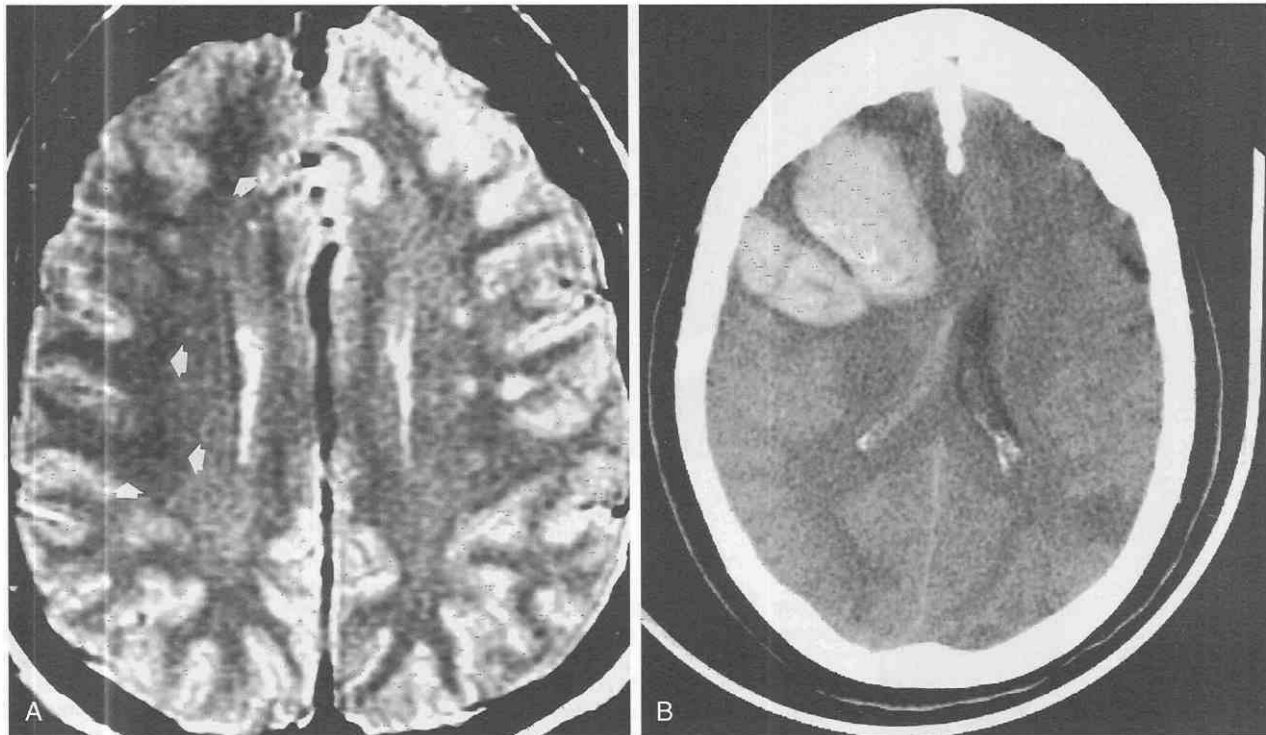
Acute left-sided weakness. A, T2-weighted axial image shows extensive subcortical low signal in the right frontal lobe (arrows). B, Unenhanced CT 36 hours later shows development of right frontal hematoma. Hypointense changes on T2-weighted images appear to have preceded hemorrhagic infarction.
